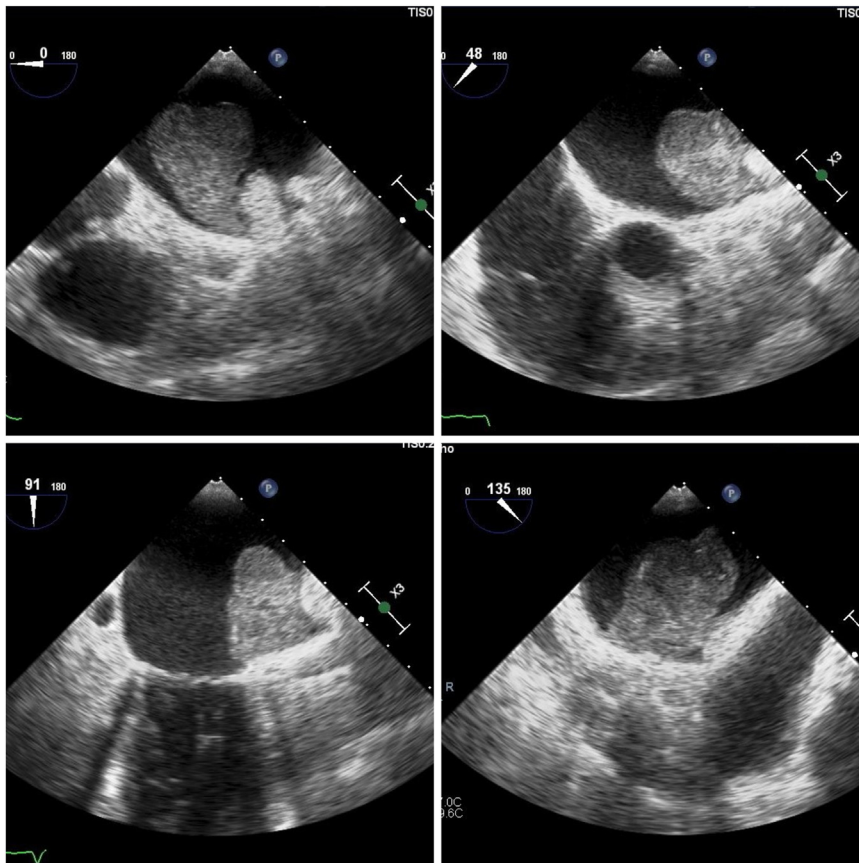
Several transesophageal echocardiography views of a large mass arising from a cul-de-sac between the ridge of the left superior pulmonary vein and the disc of the Amulet device.
